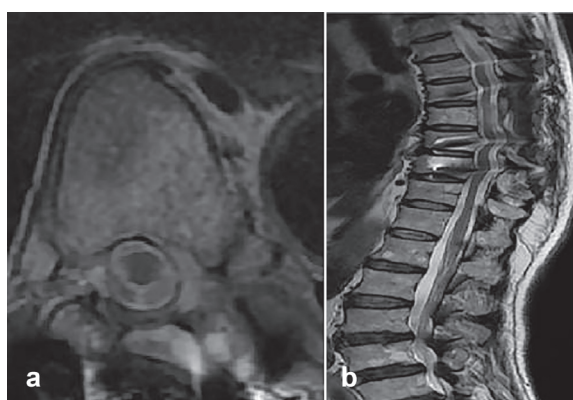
Magnetic resonance imaging a) axial T2 and b) sagittal T2 of the patient at 6 months' postoperative follow-up suggests no spinal tumor recurrence.
